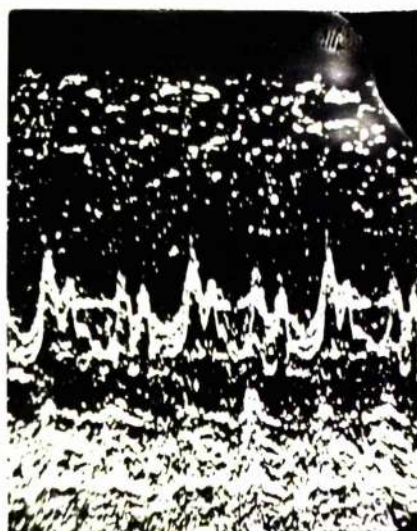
3 CASE 8 - ECHOCARDIOGRAM AND CHEST X-RAY
